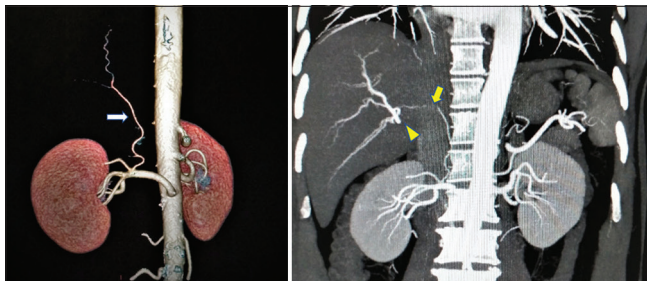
Left panel: CT angiography showing the distal origin of accessory right hepatic artery from right renal artery (arrow). Right panel: Coronal section of the abdomen showing accessory right hepatic artery coursing along the right crus of diaphragm and supplies segment VII of the right lobe of the liver (arrow). Normal right hepatic artery division is also seen (arrowhead)
